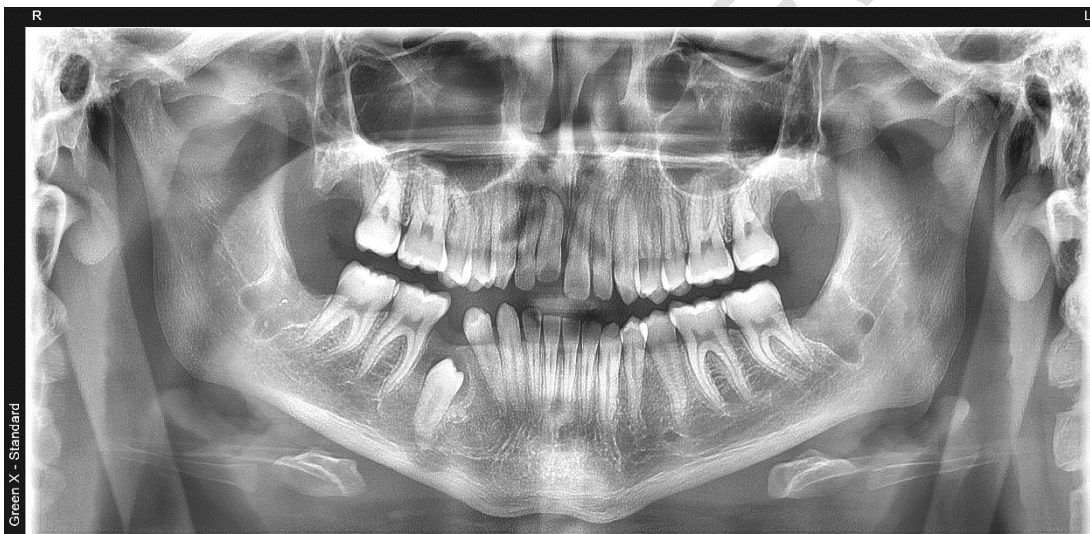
panoramic x-rays after 18 months
